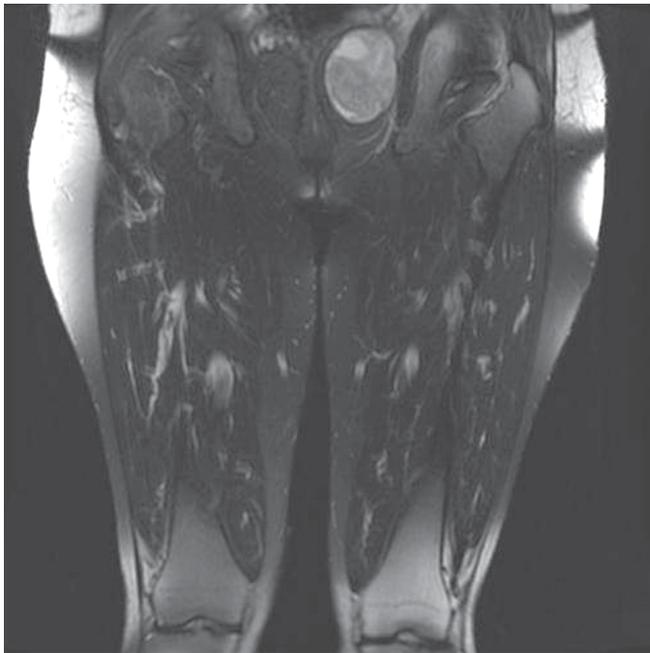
Magnetic resonance imaging revealed a mass lesion of heterogeneous intensity 5.2×5.7 cm in the left vaginal wall.
